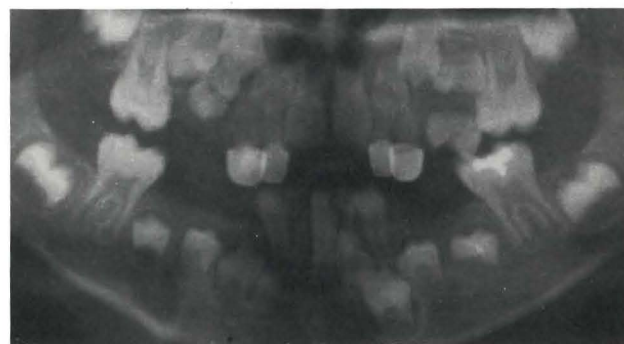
Panoramic radiograph showing continued premature and ectopic eruption of maxillary left first premolar with no further root development. Note impacted maxillary left second premolar.
